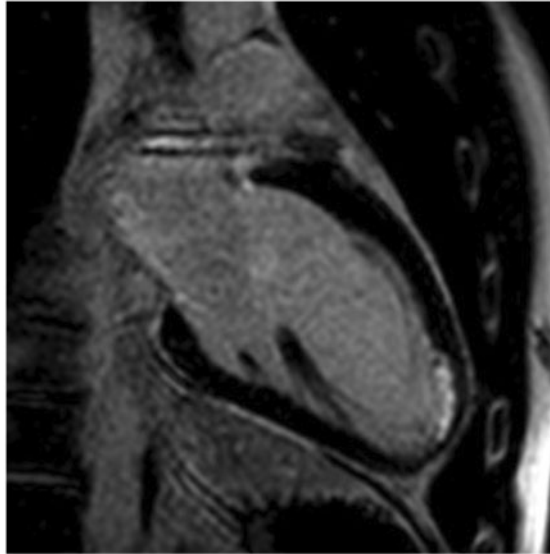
Cardiac magnetic resonance imaging slice showing a limited infarct in the apical anterior wall and part of the apical septal wall of 25–50% transmural.
